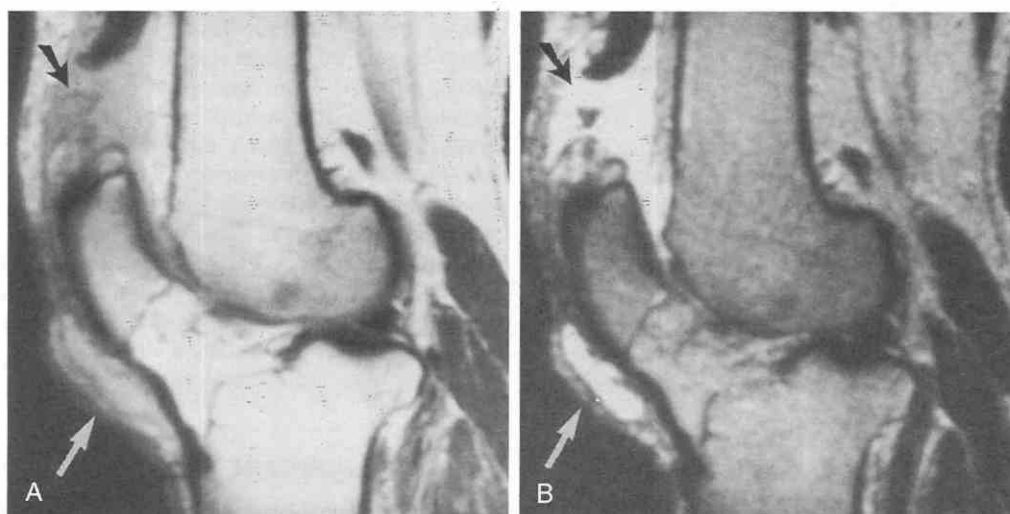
Quadriceps tendon rupture. Sagittal proton-density-weighted and T2-weighted images show complete disruption of the quadriceps tendon (black arrow). Incidentally noted is a prepatellar bursitis (white arrow).
